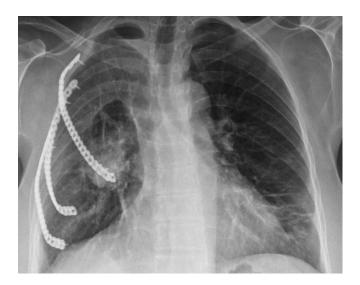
Postoperative chest X-ray at 8th month control.
